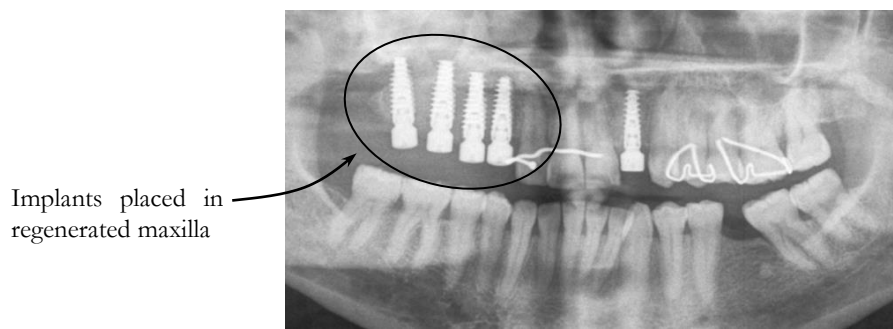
X-ray image of dental implants in regenerate
